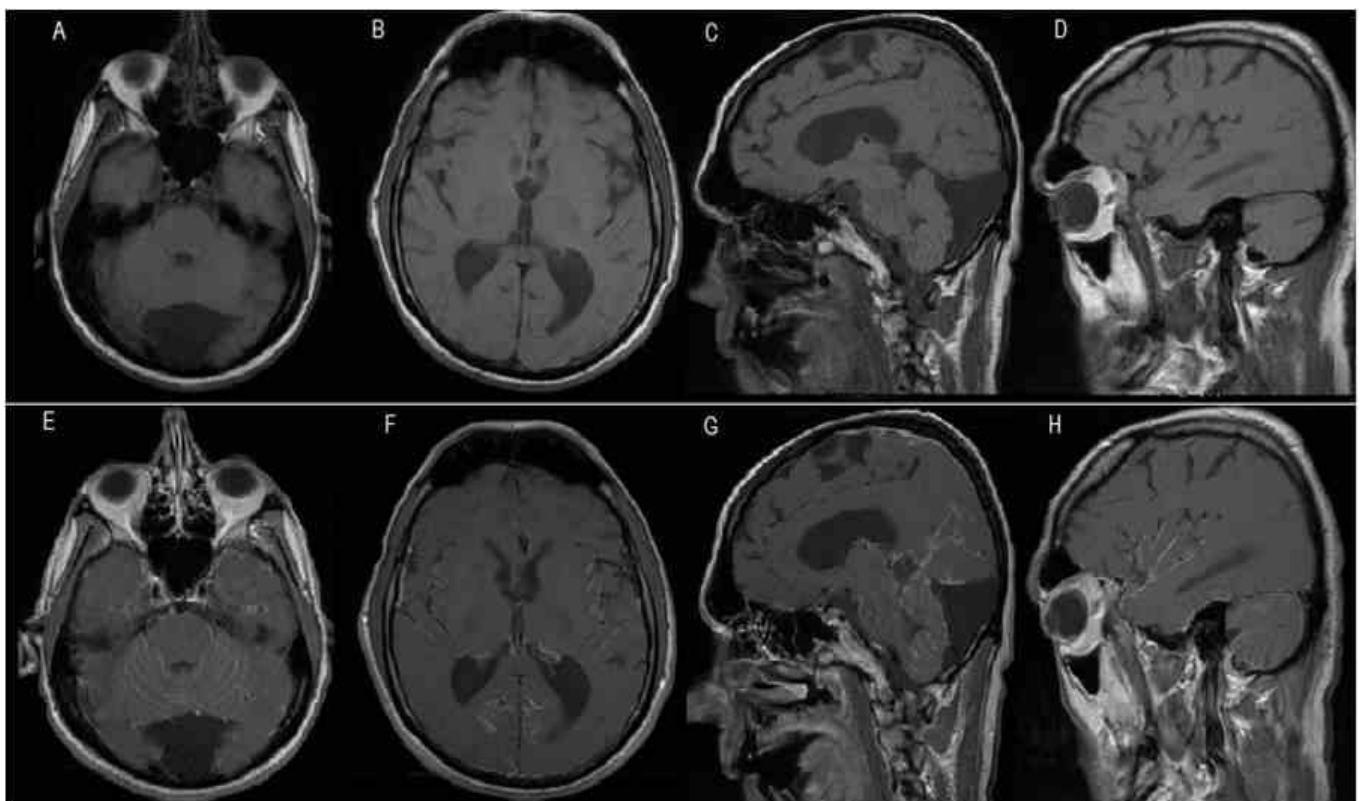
MRI Brain with and without contrast, on day 0. A-B – Axial T1 pre-contrast. C-D – Sagittal T1 pre-contrast. E-F – Axial T1 post-contrast. G-H – Sagittal T1 post-contrast.
